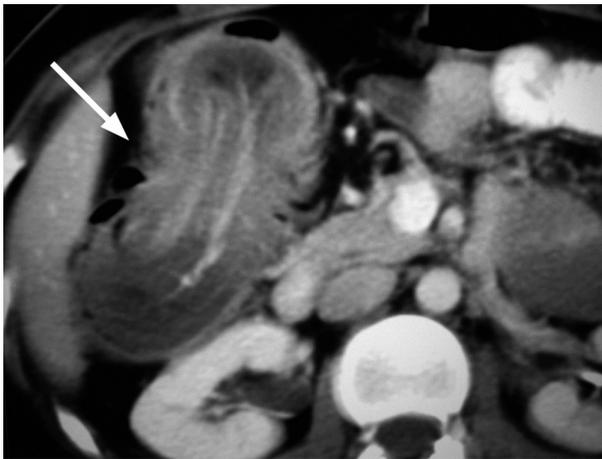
Computerized Tomography (CT) findings showing a typical sausage shaped mass (arrow) at the site of intussusception.
